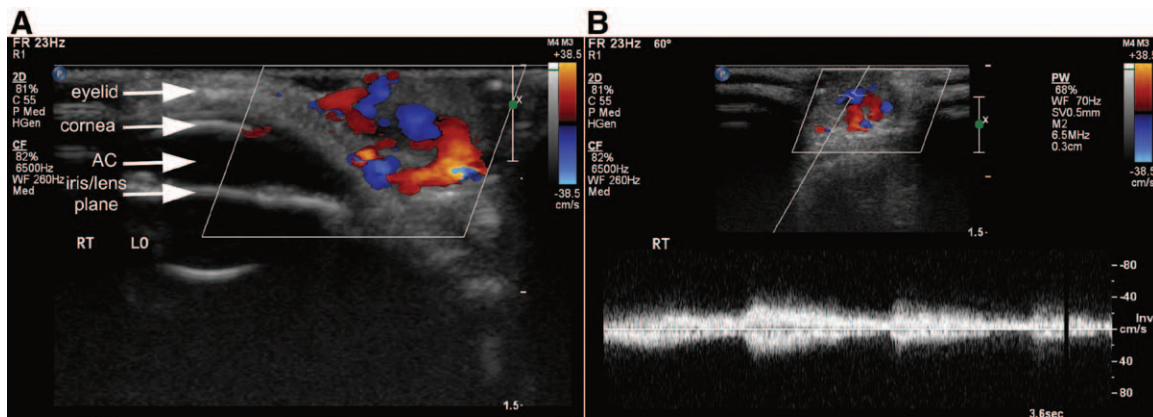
A and B, Doppler ultrasound shows high arterial blood flow.
